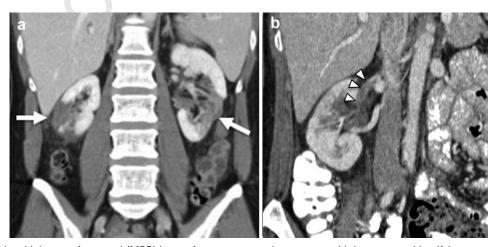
(a) Coronal multiplanar reformatted (MPR) image from a computed tomogram with i.v. contrast identifying areas of infarction in both kidneys (arrows). (b) Oblique MPR image shows thrombosis of segmental artery to the newly infarcted region in the right kidney (arrowheads).
